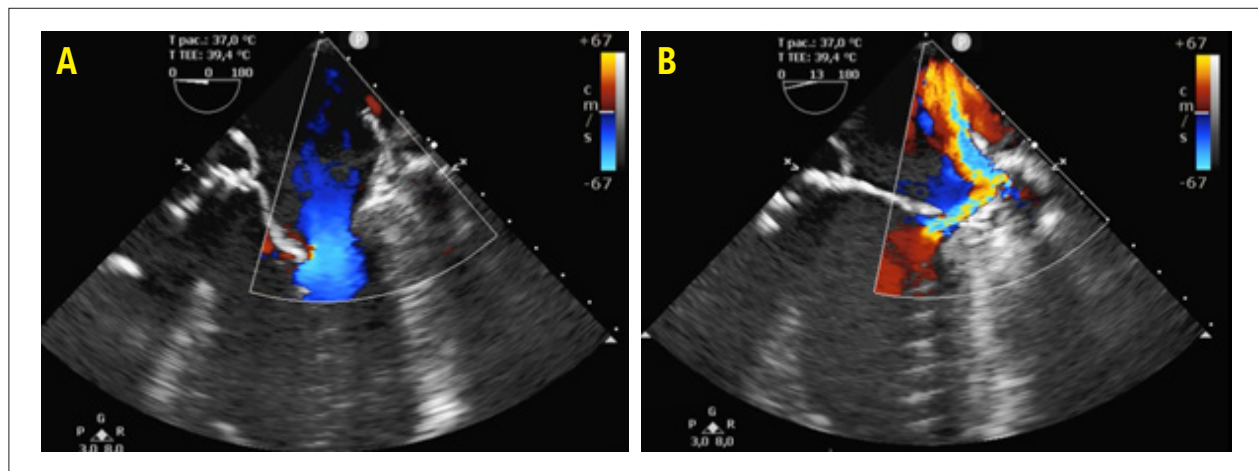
Two-dimensional transesophageal echocardiography demonstrating antegrade (A) and eccentric retrograde flows.
